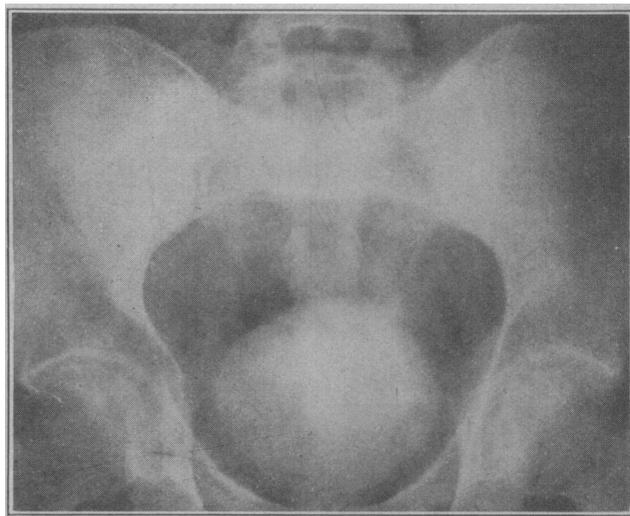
The patient received 200 c.c. of a 10 per cent. solution of sodium iodid intravenously. The roentgenogram made two hours later revealed a perfect outline of the full bladder.
